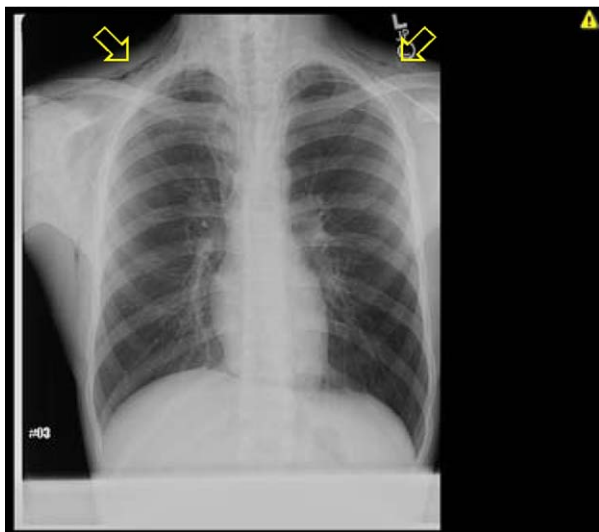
Chest X-ray study showing subcutaneous emphysema (arrows).
